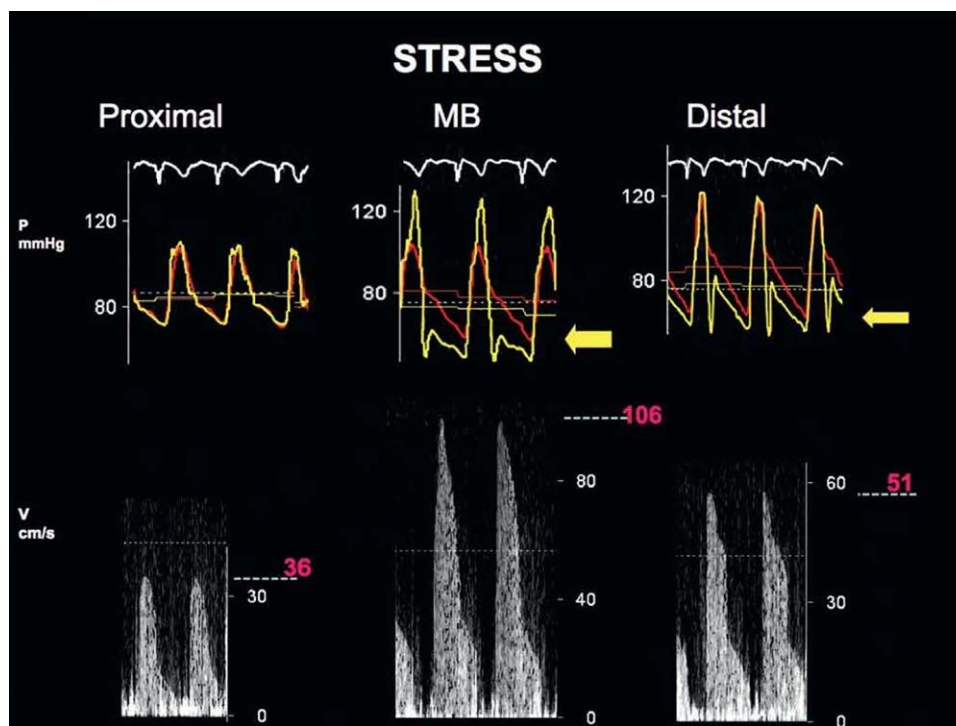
Representative readings of flow velocity and pressure. With peak stress, there is no significant change in the 2 pressure lines proximally. Within the myocardial bridge, there is systolic overshoot (yellow line) and diastolic decline in pressure, resulting in a diastolic fractional flow reserve (dFFR) of 0.74 (large yellow arrow). Distal to the bridge, there is diastolic pressure recovery with a dFFR of 0.88 (small yellow arrow). Stress Doppler peak velocities are 36, 106, and 51 cm/s, respectively. (Used with permission from Lin et al. *J Am Heart Assoc.* 2013)
